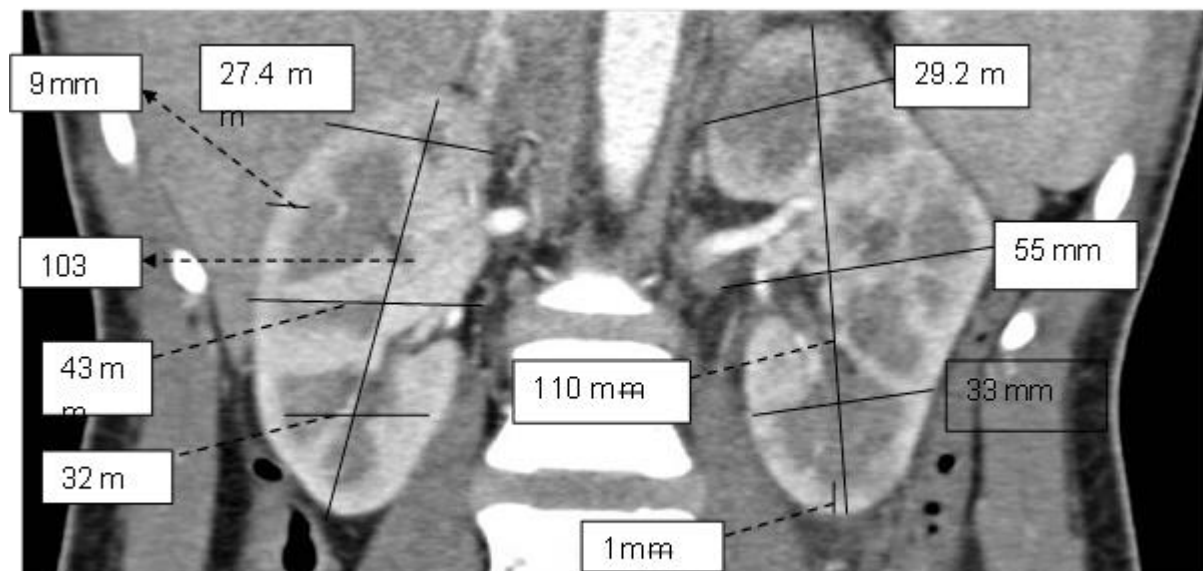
coronal CT image for Male (33 years) show site measurements of RT, LT Kidney length, width and cortex thickness diameter.
